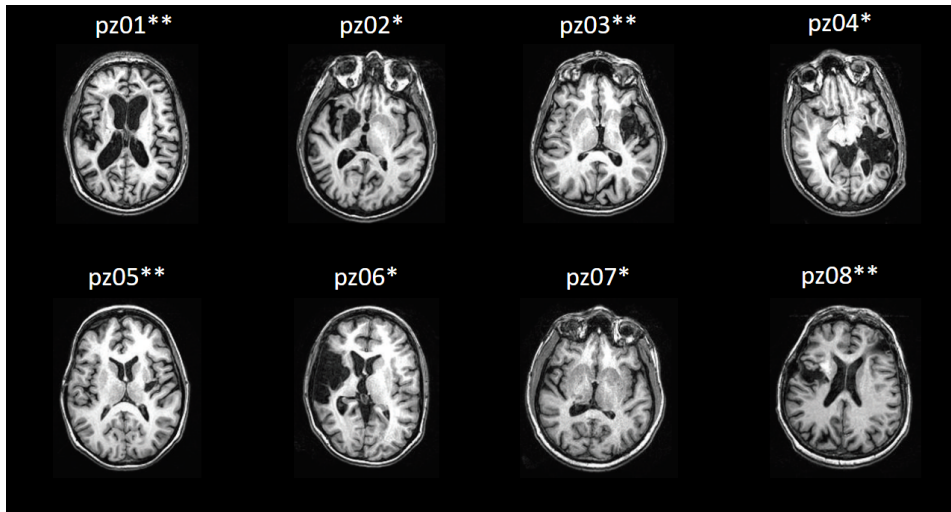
The site of cerebral infarction as determined from the T1-weighted structural MRI.  indicates patients with FES carryover; * indicates patients with no FES carryover.
